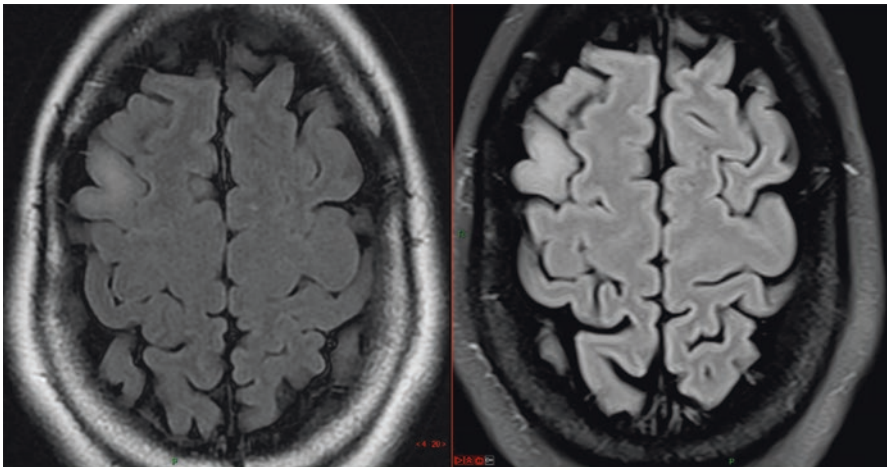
Suspected DLGG of incidental discovery in a 50-years old lady on axial FLAIR-weighted MRI. No evolution was evidenced over three years of follow-up (*left*: June 2013, *right*: June 2016). Active surveillance was recommended. The patient enjoys a normal life, with no symptoms
